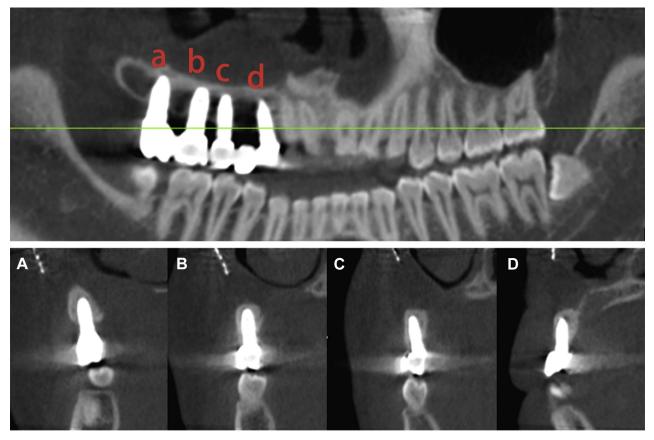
Radiographic images showing bone loss at 5 years after implant placement. *A*, *B*, *C*, and *D* represented the magnifying images of the implants *a*, *b*, *c*, and *d* in the upper image retrospectivelly.
